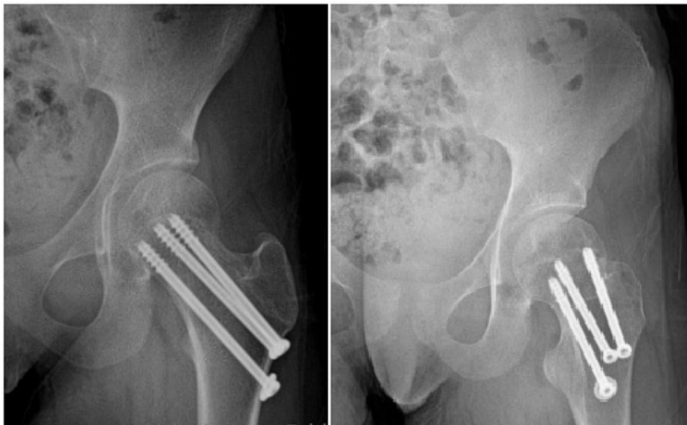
Postoperative follow-up of the fracture with 3 screws fixation radiographs
